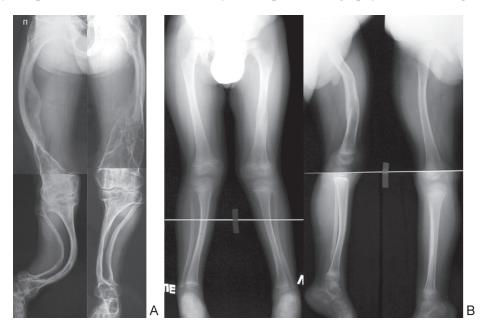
X-ray telemetry of the lower extremities: A – patient with OI type III, B – with OI type IV
